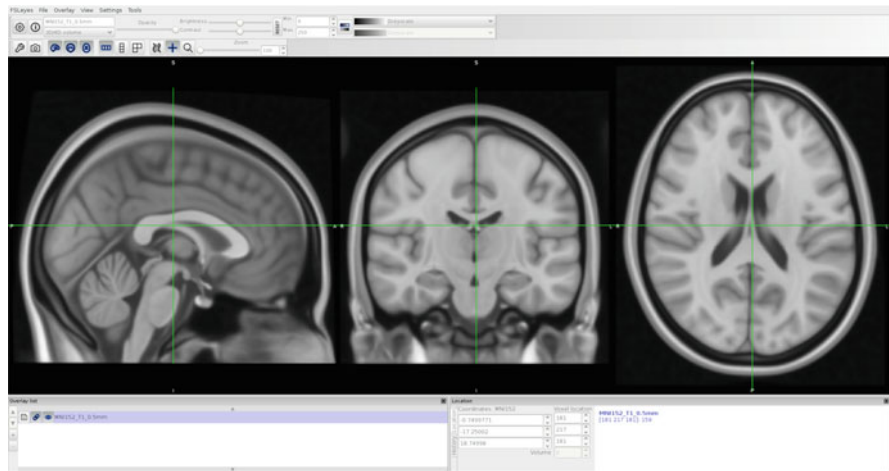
T₁ weighted MRI scan of the human brain shown in sagittal, coronal, and axial views
